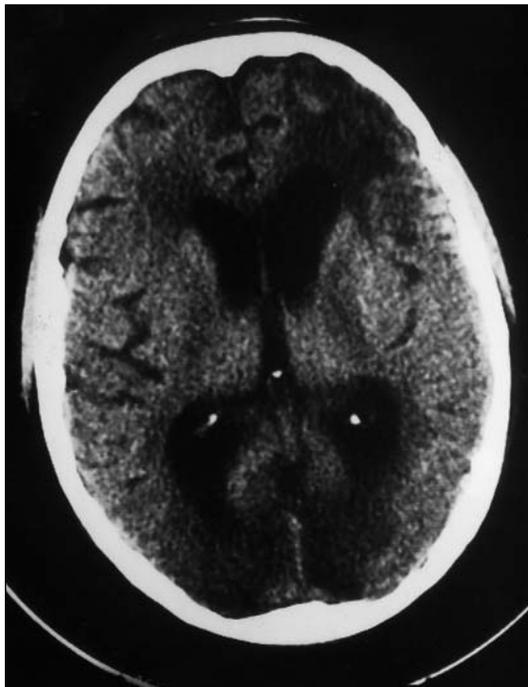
Computed tomography of the brain revealing a two contrast-enhancing mass lesion in the left frontotemporal area.
